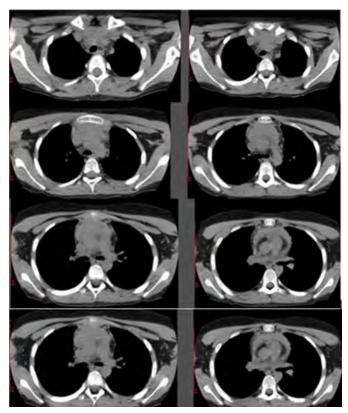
CT of thorax from March 2022.
